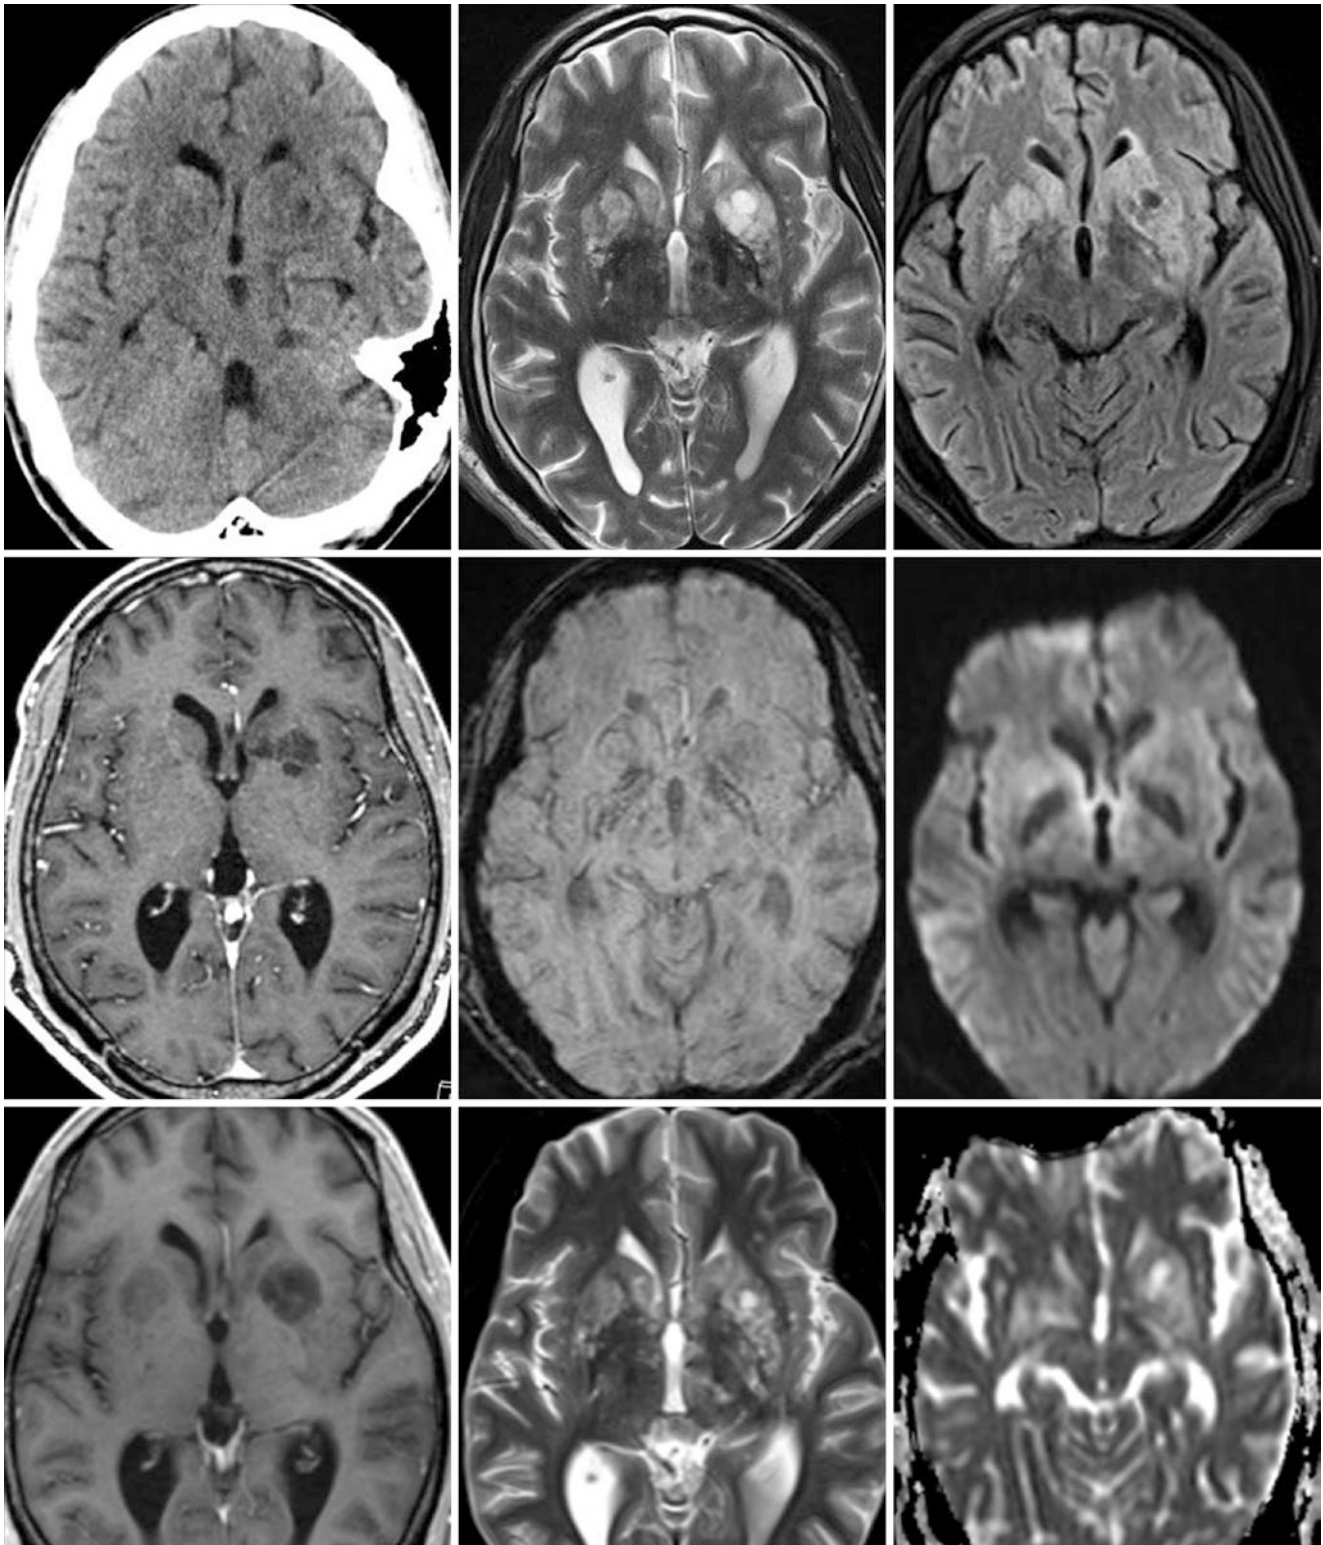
Comparison case of cryptococcal meningitis with dilated PVSS. *Top row:* a 31 year old with HIV and AIDS had diffuse low attenuation throughout the basal ganglia on NECT (*left*). On T2WI (*middle*), there were diffusely markedly dilated PVSSs bilaterally throughout the basal ganglia, which only partially suppressed on FLAIR (*right*). *Middle*
